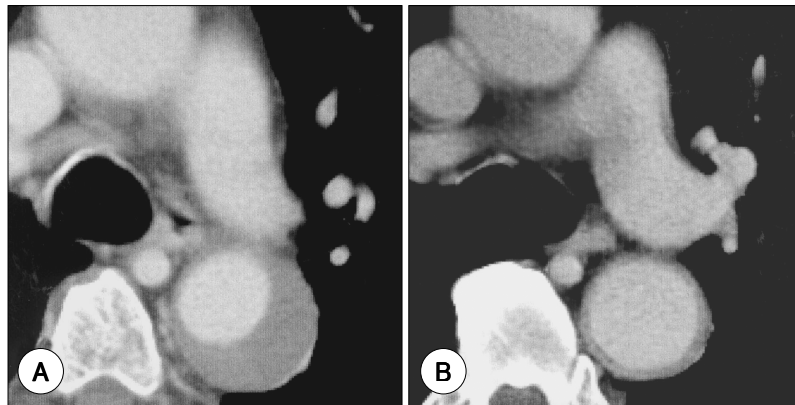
Morphologic change of aorta in intramural hematoma patients at long term follow-up. A : CT angiography in a 65-year-old male shows crescent-shaped wall thickening with no enhancement after contrast injection, B : follow-up CT angiography after 17 months shows increase in true lumen area and decrease in total outer diameter of aorta.
